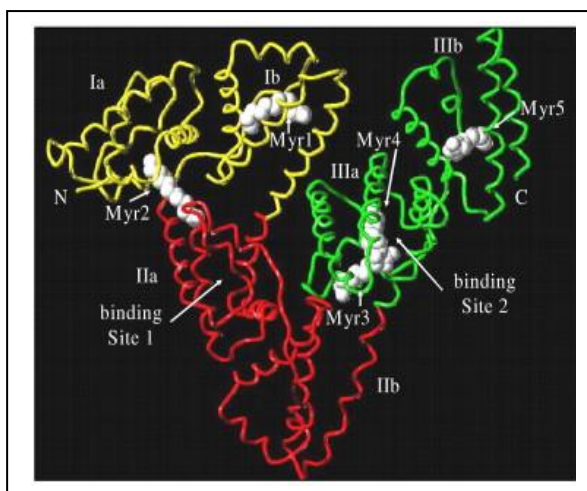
Three-dimensional structure of Human Serum Albumin, created by X-ray structure analysis [73].
